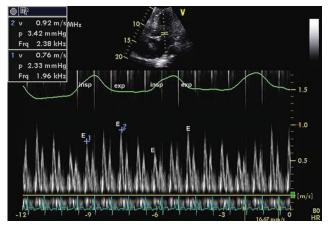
Cardiac tamponade: PW Doppler recording of mitral inflow assessing respiratory variation in a patient with cardiac tamponade. Note that the respirometer denotes the onset of inspiration (insp) and expiration (exp). The peak E-wave in inspiration (1 = 76 cm/sec) and expiration (2 = 92 cm/sec) are recorded. The method for determining respiratory variation of mitral inflow is from expiration with the formula (expiration — inspiration)/expiration or, in this example, (92-76)/92=17%. Several measurements should be made and averaged. Usually, >30% respiratory variation in mitral inflow is considered abnormal and likely present in this patient when averaging measurements over several cardiac cycles.
